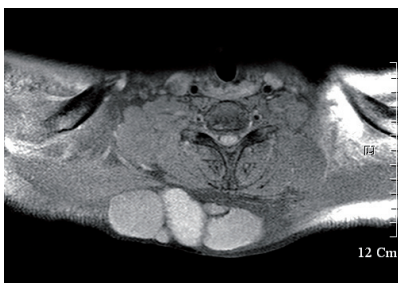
Magnetic resonance imaging findings (T1 fat suppression image) of five epidermal cysts.
